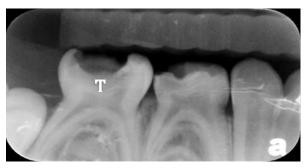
Radiographic image of the primary mandibular right second molar.
